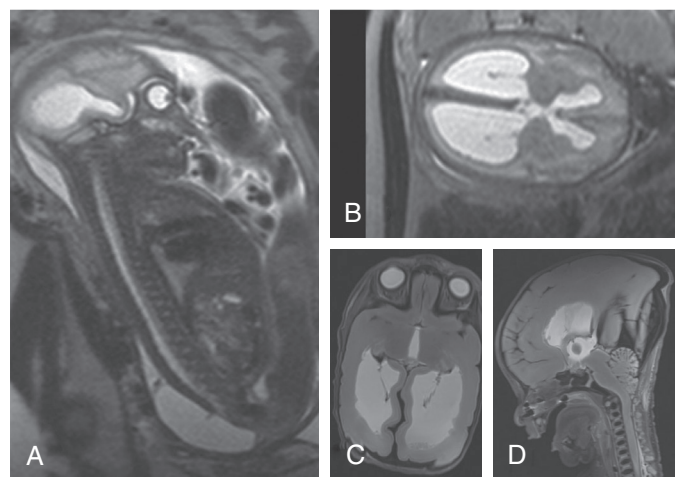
MRI of fetal pathology. A, Fetus with sacral myelomeningocele at 30 weeks' gestation. B, Ventriculomegaly in the same fetus as in A. C, MRI can also be used for postmortem examination, here in a 33-week-old fetus, demonstrating ventriculomegaly with heterotopic foci in the ventricular walls. D, Chiari II malformation of the brainstem. (Courtesy Filip Claus, Aalst, Belgium.)
